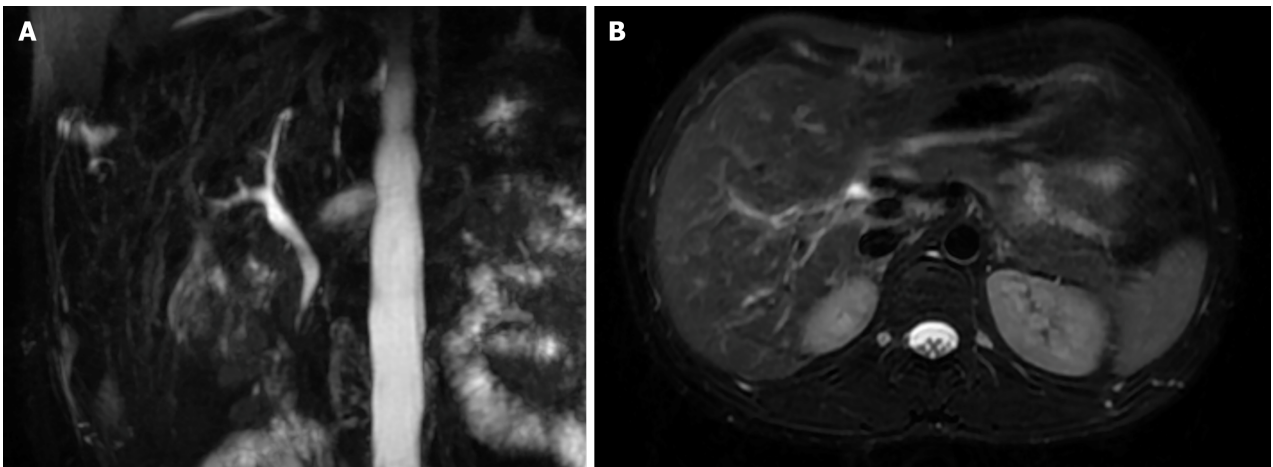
Magnetic resonance imaging and magnetic resonance cholangiopancreatography after surgery. A and B: Two weeks after surgery, follow-up magnetic resonance imaging and magnetic resonance cholangiopancreatography showed no intrahepatic or extrahepatic bile duct strictures or dilatation.
